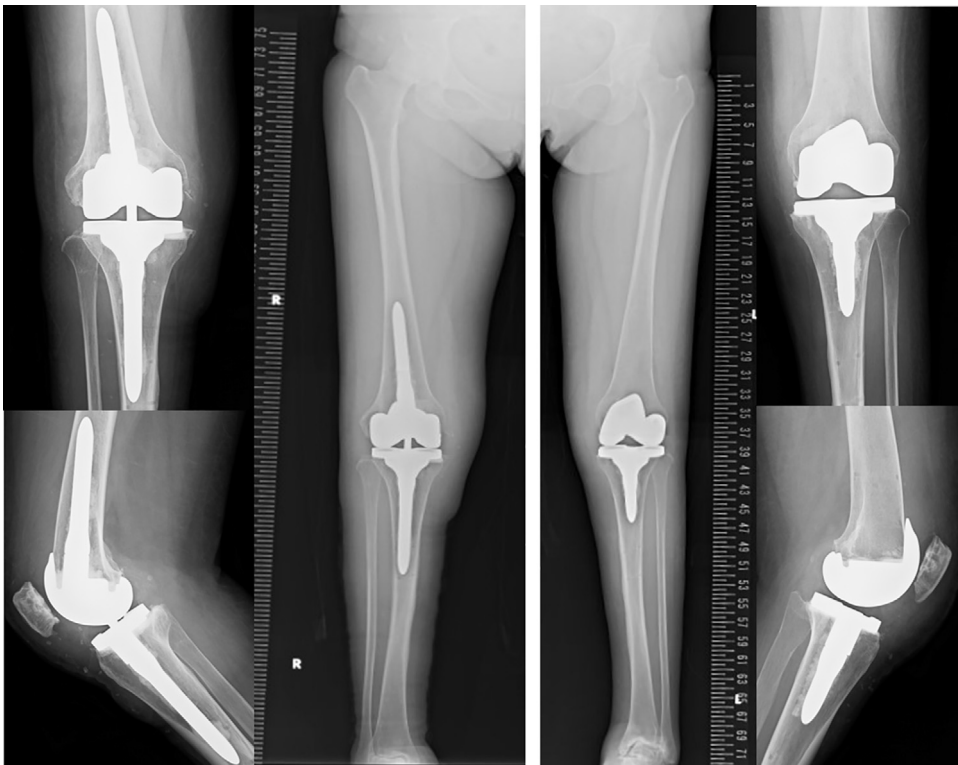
Postoperative radiographs. The radiographs show the improved alignment of the lower limbs.
